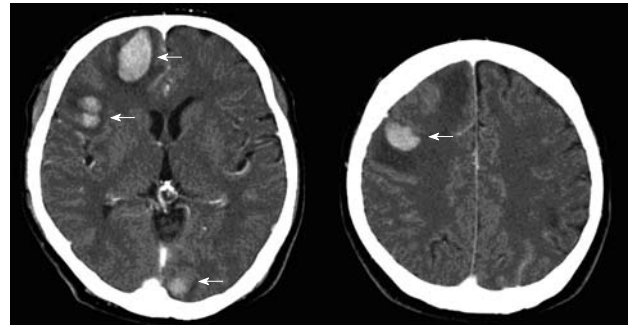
Contrast-enhanced computed tomography scan shows multifocal hemorrhage in the right frontal lobe, right temporal lobe, left occipital lobe, and right parietal lobe (white arrows).
